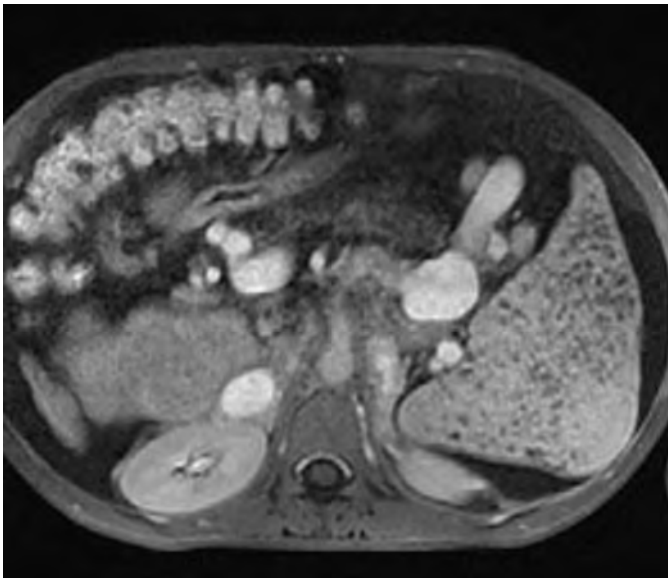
Gamna-Gandy bodies in a patient with cirrhosis and portal hypertension. Portal venous phase, axial, T1-weighted FAME (fast acquisition with multiphase enhanced fast gradient recalled echo with three-dimensional Fourier transformation) MR image after gadolinium enhancement demonstrates numerous, small, hypointense nodules throughout the spleen.
